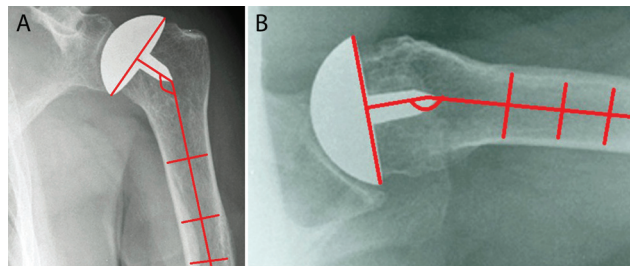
Radiographic evaluation of implant positioning in partial shoulder resurfacing arthroplasty. (A) Measurement of the cervical-diaphyseal angle in anteroposterior view. (B) Measurement of the retroversion angle in axillary view.
